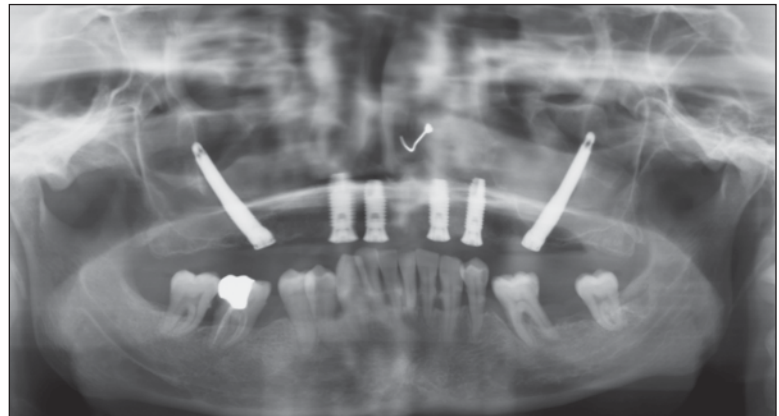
Case 2: Extraoral panoramic radiographic image following the placing of 4 conventional and 2 zygomatic implants.
